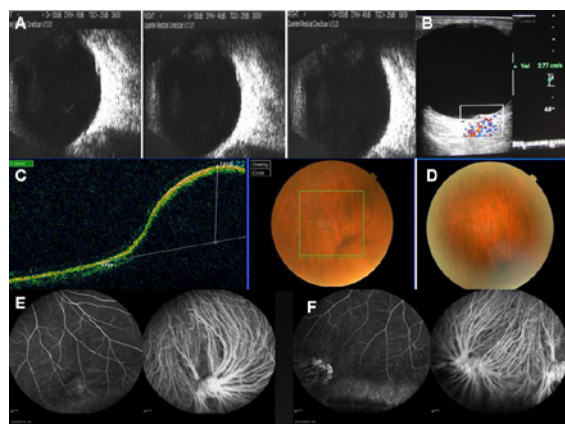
Ultrasonography, OCT, Angiography, and CDFI in case 2. A Ultrasound examination showed mild vitreous opacities and posterior vitreous detachment. A dome shaped lesion of 1mm × 3mm on the peripheral globe wall with high reflective smooth surface and low internal reflectivity could be found on the 5 o'clock meridian. From left to the right, the pictures showed the decreasing lesion height while a pressure was given to the globe. B By CDFI, vein flow signal with a velocity of 2.77cm/s was found inside the lesion. C Spectral domain OCT showed a crescent elevated area in the inferior fundus, large diversion of the choroidal veins could be seen converging toward this lesion. The intact neuralretinal layer and the retinal pigmental epithelial layer bulged into the vitreous in good continuity with a 1215 µm height dome shape. The reflectivity under the RPE layer was lowered. D When firm pressure was applied for seconds on the globe, the lesion collapsed. E During venous phase of ICGA, density diversions of filled choroidal vein were seen converging into a rope knot like enlarged vortex vein ampulla in the lesion. And in the corresponding FFA, slight uplift and fluorescence filling of the vortex vein ampulla could be seen. F At the area of coagulation, fluorescence dye and shelter could be found by FFA and density diversions of filled choroidal vein were also found by ICGA, but without bulging.
